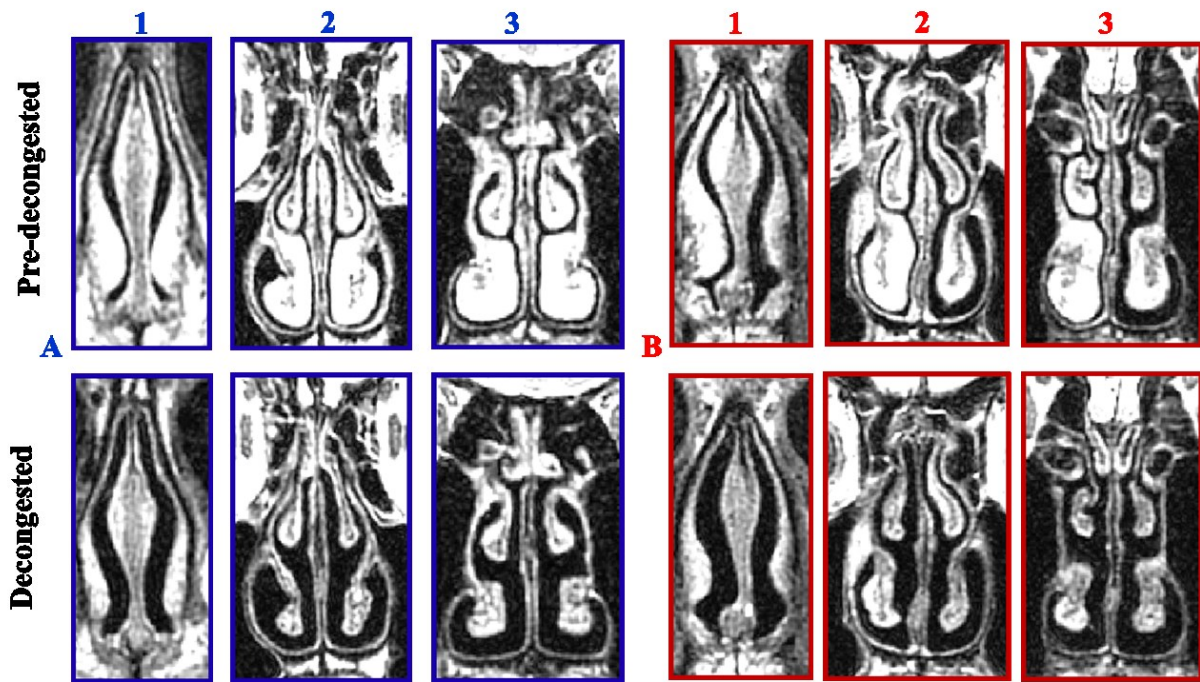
MRI images of nasal anatomy pre- (top) and post- (bottom) decongestion, for Subject A left and B right
